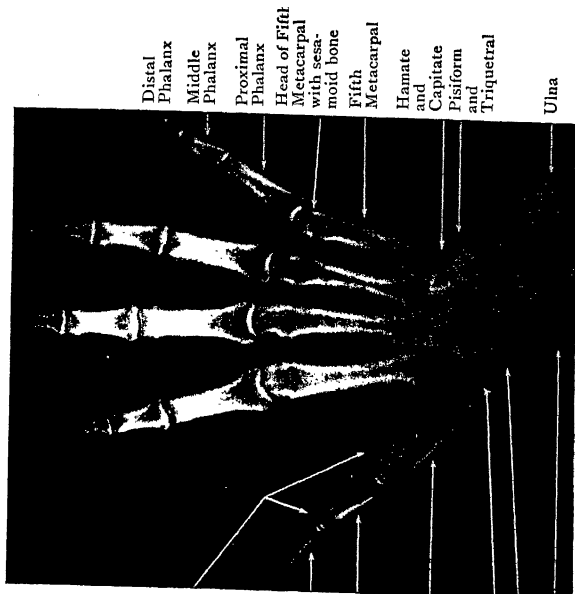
Radiograph of Wrist and Hand of man aged 25.
